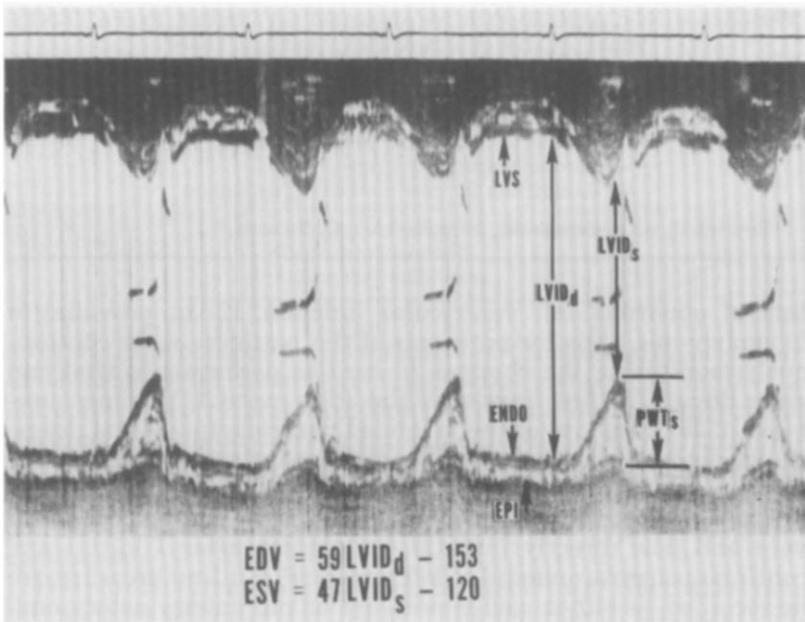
Diastolic and systolic dimensions from the echocardiogram can be used to calculate end-diastolic volume (*EDV*), end-systolic volume (*ESV*) and ejection fraction. *LVS* = left ventricular septum. *LVID_d* = left ventricular internal dimension in diastole; *LVID_s* = left ventricular internal dimension in systole; *ENDO* = endocardium; *EPI* = epicardium and *PWT_s* = posterior wall thickness in systole (Reprinted, with permission, from Rackley, C. E., *et al.*¹⁶)
